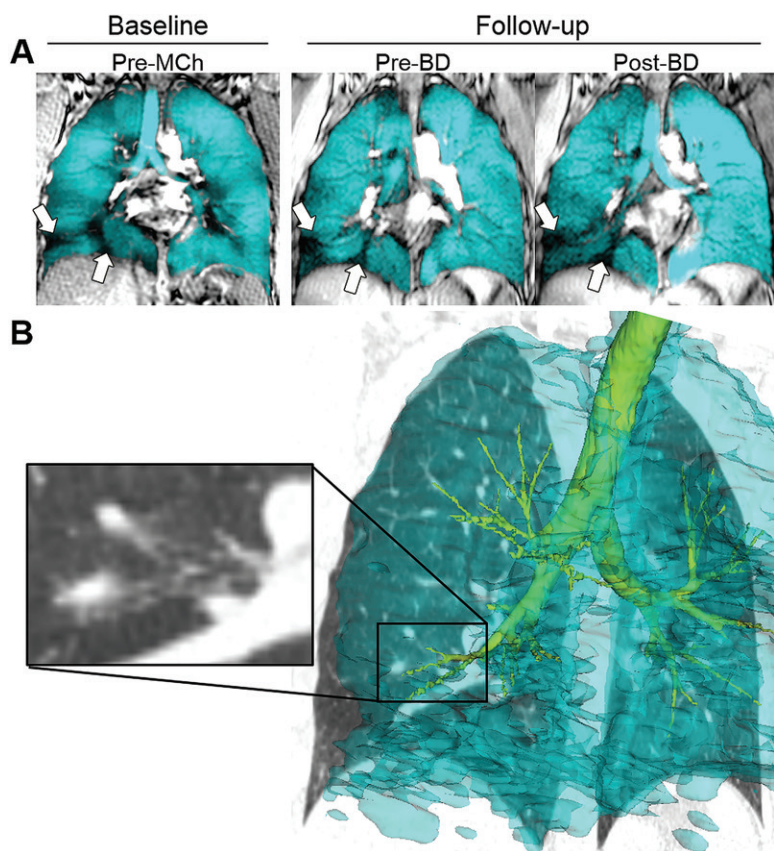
Images show helium 3 (^3He) MRI ventilation in a 28-year-old man (participant S03) with mild-to-moderate asthma and stable ventilation between baseline and follow-up. A, Center coronal section ^3He ventilation MRI (cyan, administered as an inhaled contrast agent) coregistered to anatomic hydrogen 1 (^1H) MRI (gray scale) for baseline pre-methacholine challenge (pre-MCh) and follow-up before and after bronchodilator (pre-BD and post-BD, respectively). Persistent defects between visits are shown (arrows). B, Follow-up three-dimensional ^3He MRI shows ventilation coregistered to CT with three-dimensional airway tree at oblique angle. Inset (coronal view) shows RB8 bronchus subsegmental bifurcation. Inferior daughter branch leading to persistent defect between baseline and follow-up appears narrowed compared with superior daughter branch. Participant S03 was a man with mild-to-moderate asthma (baseline and follow-up, respectively: age, 28 years and 35 years; forced expiratory volume in 1 second, 3.97 L and 4.19 L; ventilation defect volume, 340 mL and 260 mL).
